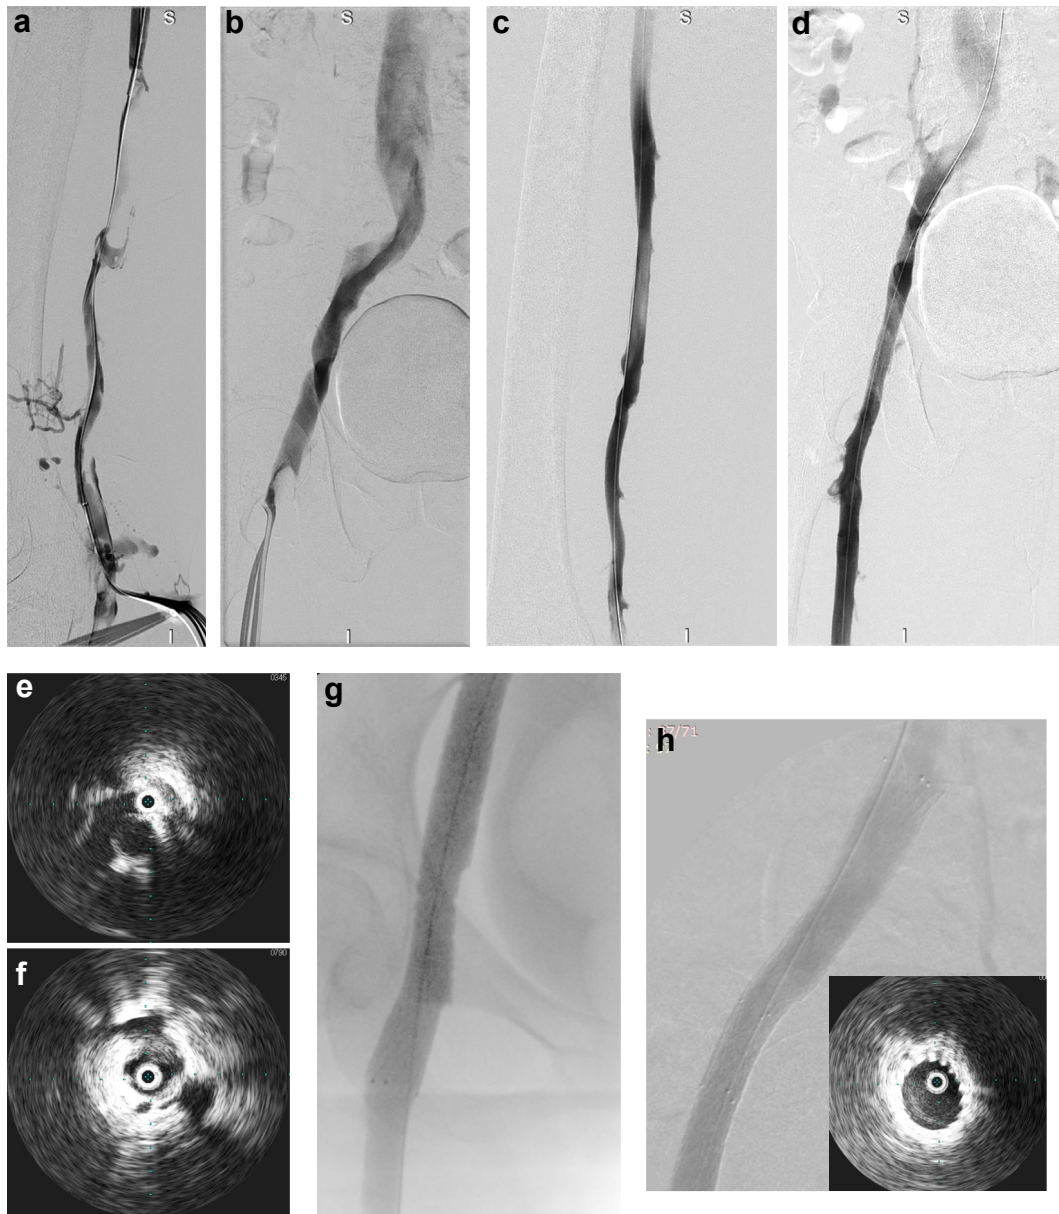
Iliofemoral deep vein thrombosis (DVT) intervention, thrombectomy, and stenting. a, Left popliteal access with the patient in a prone position, venogram indicating femoral vein thrombus. b, Venogram through the catheter positioned in the distal common femoral vein (CFV), indicating some thrombus in the CFV and a diseased common iliac segment. c,d, Post-thrombectomy venogram using the ClotTriever Thrombectomy System (INARI Medical); the vast majority of thrombus has been removed. e,f, Intravascular ultrasound (IVUS) imaging confirms disease/compression at the proximal common iliac vein and disease/residual thrombotic material at the CFV—these areas need to be stented to provide optimal inflow and outflow. g,h, Poststenting and venoplasty venogram; two Venovo stents (BD Medical), 160 × 120 mm proximally and 140 × 100 mm distally, were placed allowing brisk flow through the previously thrombosed iliofemoral segment. Notice the IVUS images confirming appropriate stent expansion.
